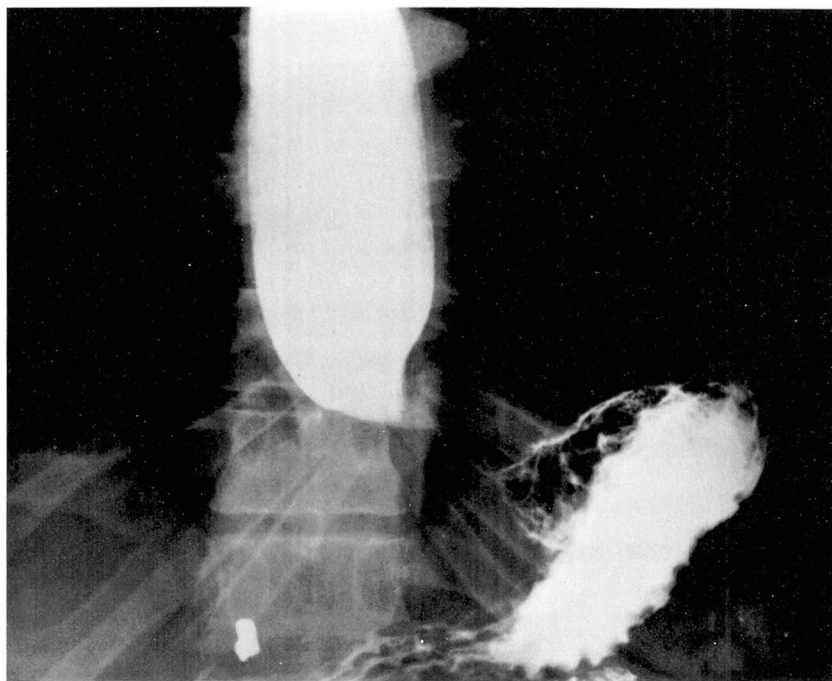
Barium meal showing dilatation of the esophagus with a tapered narrowing at the esophagogastric junction (case 1). Roentgenographic diagnosis was achalasia.
